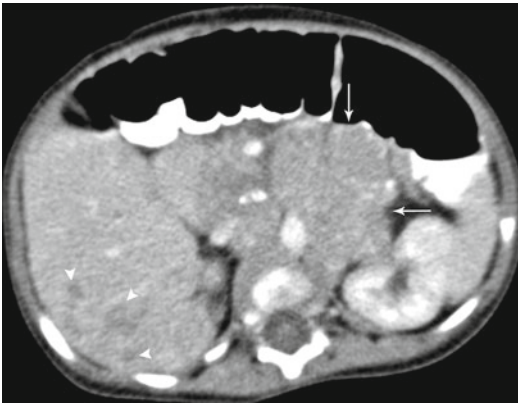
Neuroblastoma. Contrast-enhanced axial CT images in a 5-month-old girl with stage 4S Neuroblastoma (arrows). CT image reveals a heterogeneously enhancing left adrenal mass (arrows) and multiple low attenuation liver metastases (arrowheads)
